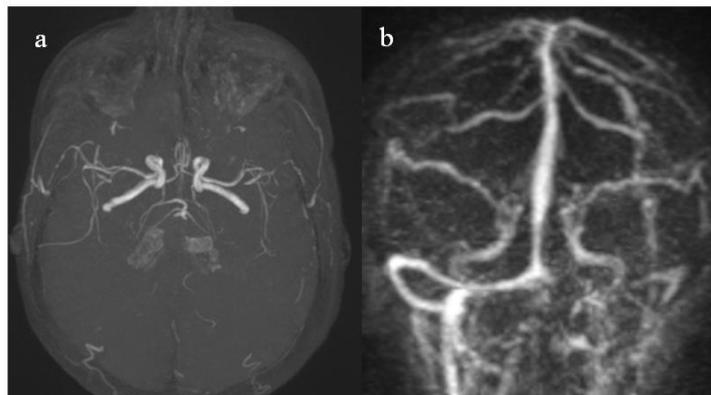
Vascular sequences of the brain MRI.
